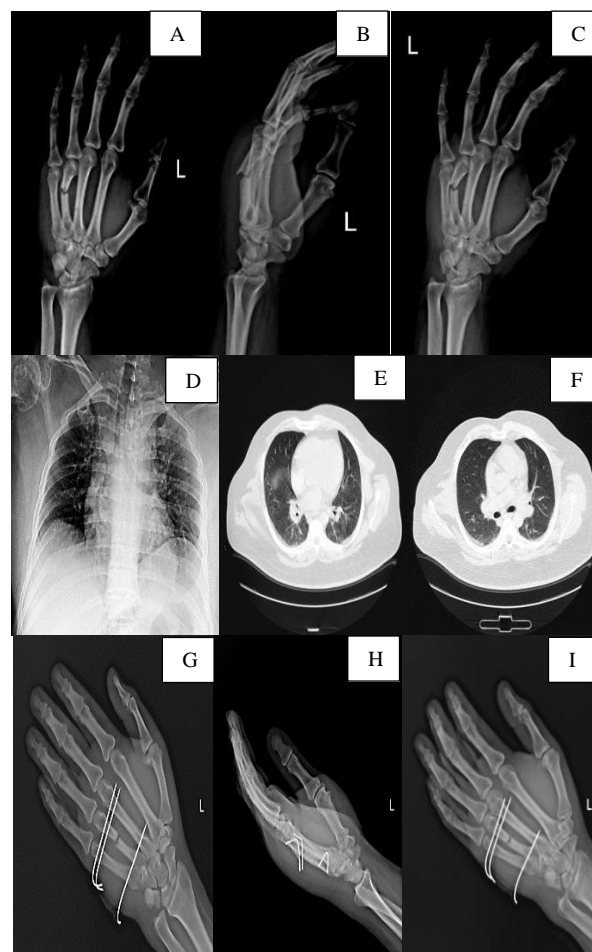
Case 2: A-C) preoperative radiographs of the patient, D) chest X-ray, E and F) chest computed tomography (CT) scan, G-I) postoperative radiographs
